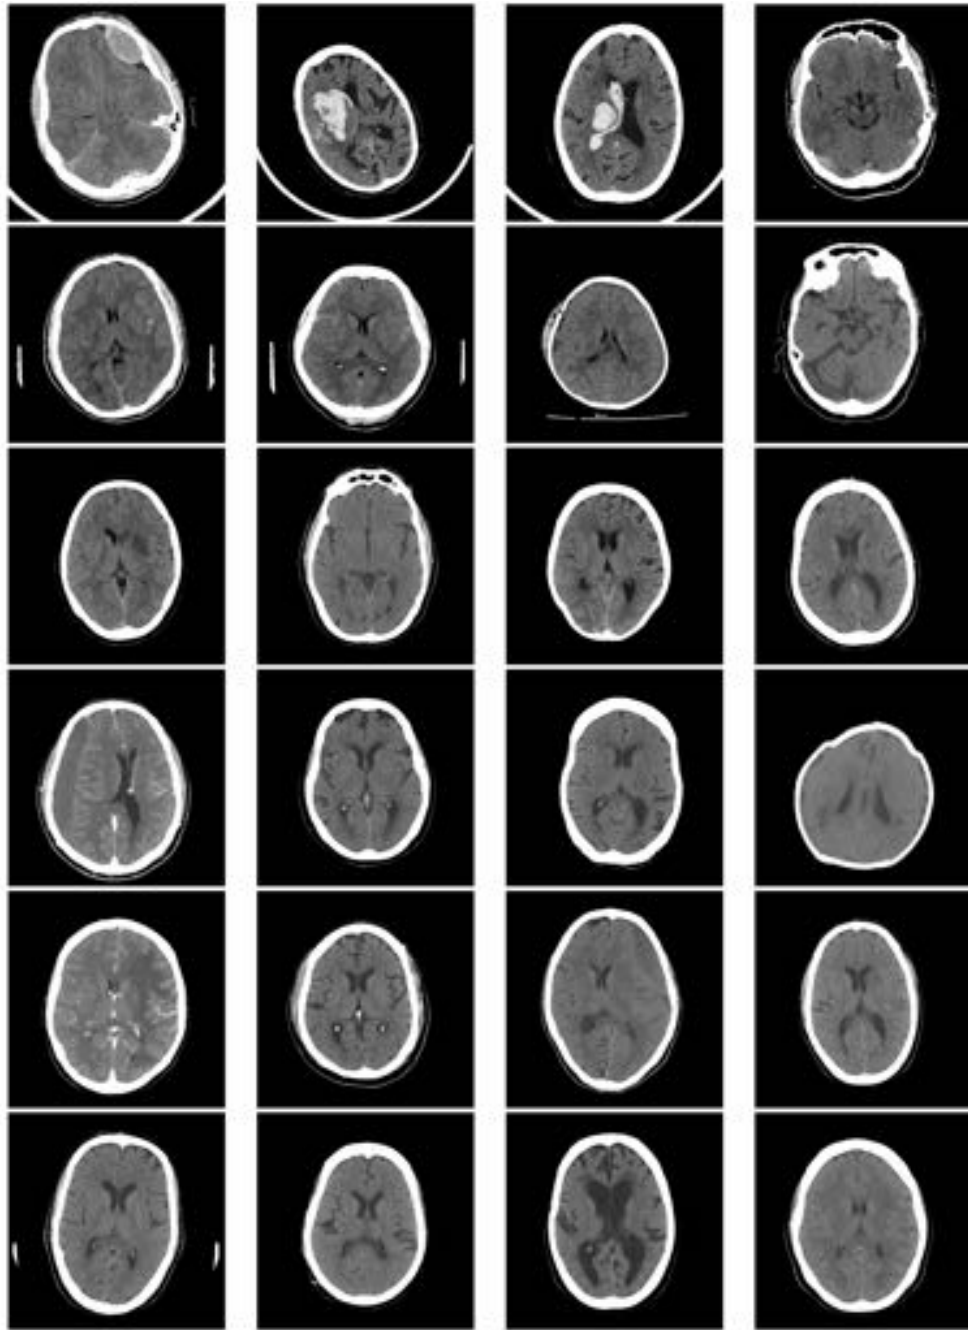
CT scans of the TBI Cases used in experiments.
